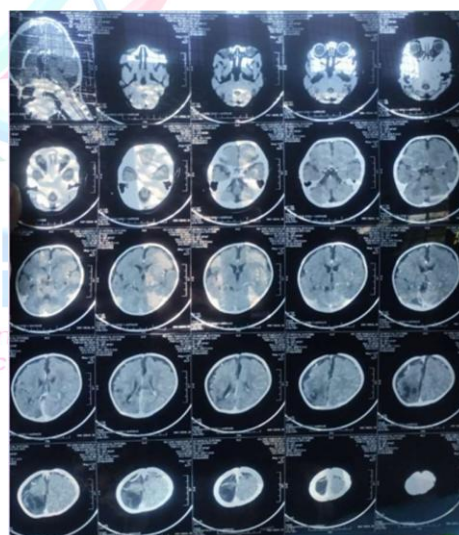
Brain CT Scan showing local atrophy
